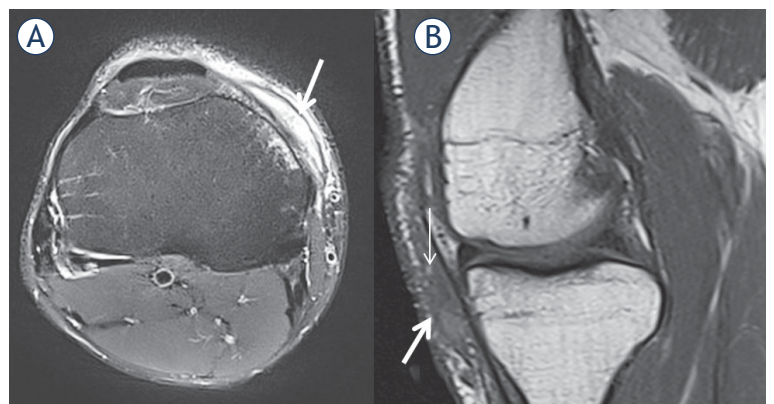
ML lesion type 3. A 34-year-old male after a distortion. On axial proton density fat-suppression (PDFS) MRI (A) a fusiform fluid collection with hypointense debris is demonstrated between the deep subcutaneous fat and layers of medial patellofemoral ligament (arrows). On T1 weighted sagittal image (B), in moderately hypointense collection several fat globules are visible (thin arrow).
